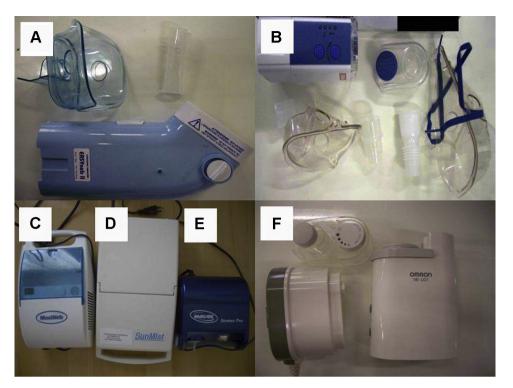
Nebulizers jet (B–D), ultrasound (A, B and F).
